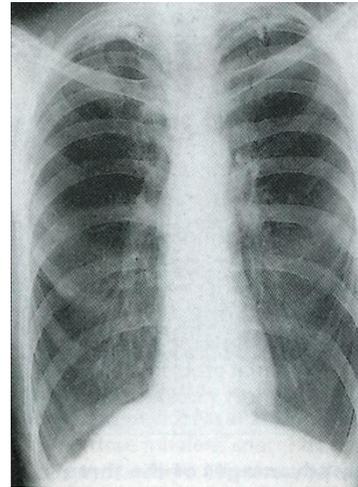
Emphysema. The PA chest X-ray shows hyperinflation of both lung fields, producing depression of both diaphragms and a characteristic long, thin mediastinum. There are also calcified lesions and some scarring at both apices and both hila as a result of old, healed tuberculosis.
